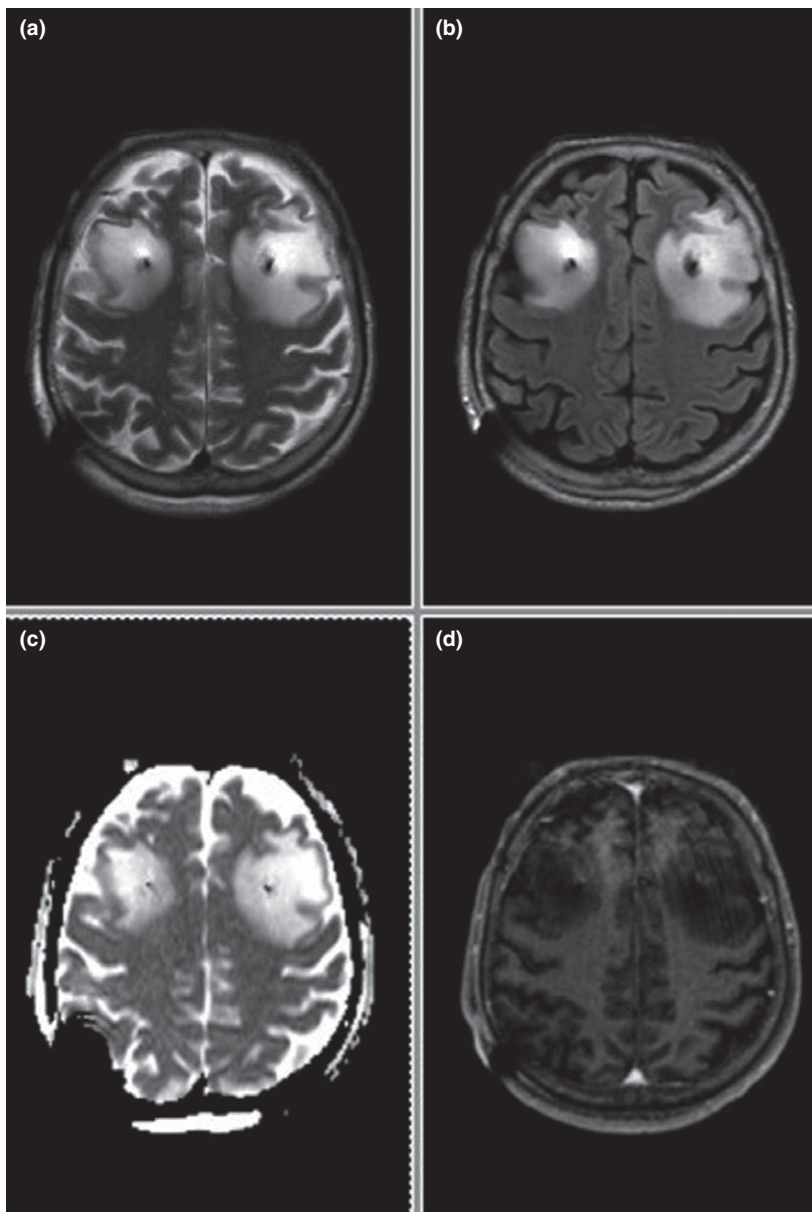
Axial magnetic resonance imaging features of peri-lead edema (patient 1, post-operative day 8). Peri-lead edema appears hyperintense in (a) T2 and (b) fluid-attenuated inversion recovery images with (c) high apparent diffusion coefficient and (d) no significant enhancement in T1 post-gadolinium images.
